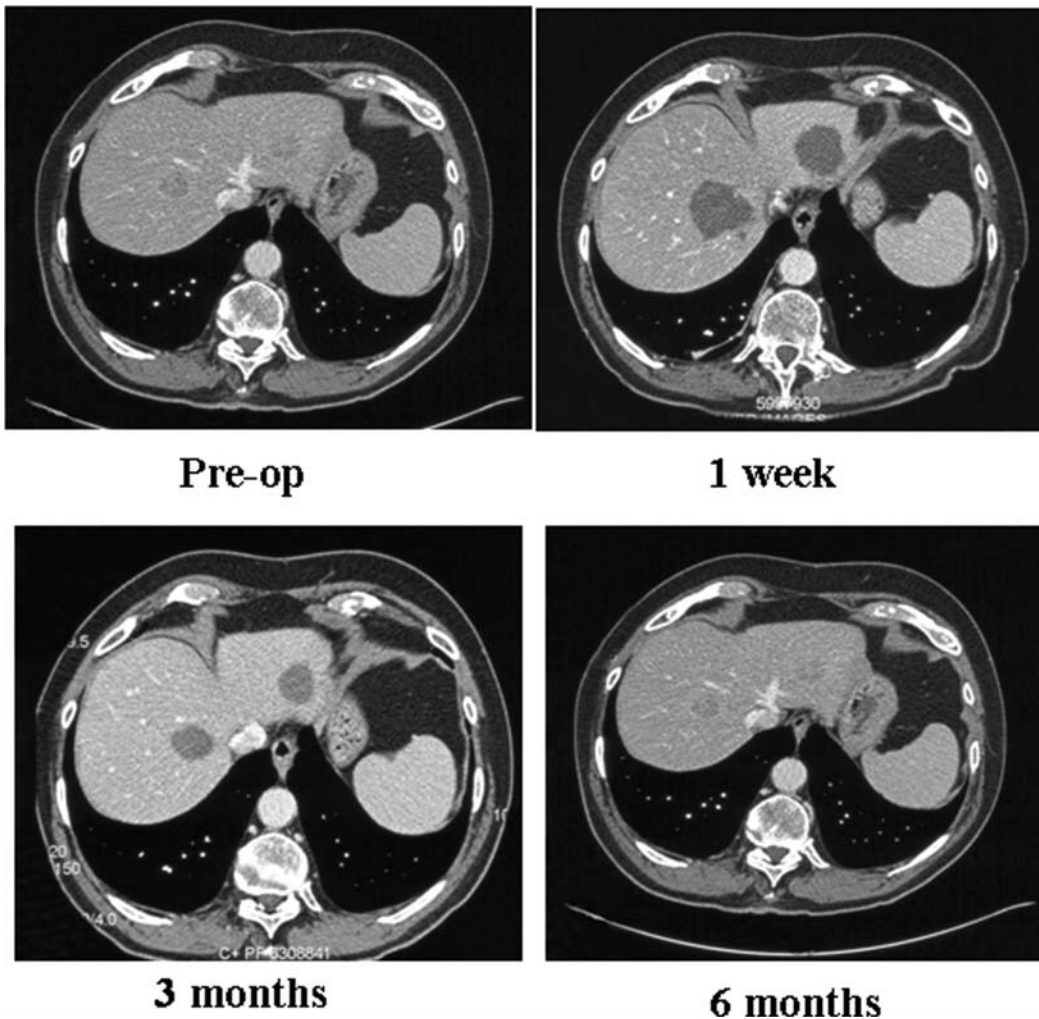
Postoperative surveillance with tri-phasic CT scan.
